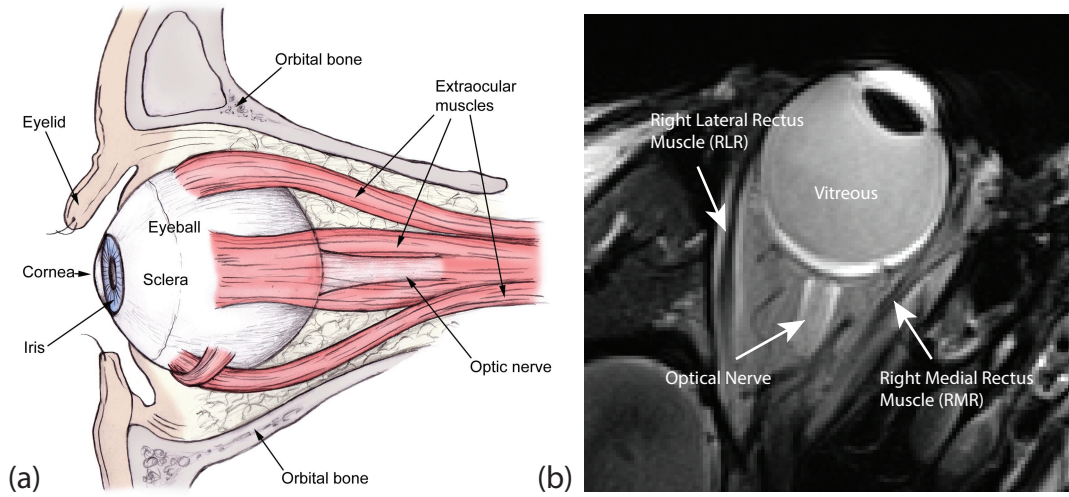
(a) Human eye anatomy showing extraocular muscles [128] and (b) T_2 -weighted axial image of the right eye using MRI scanning.
